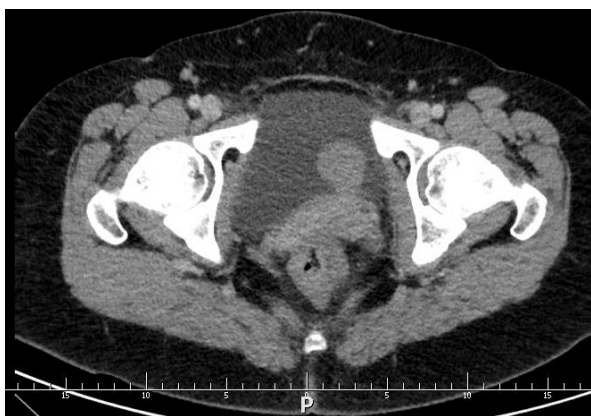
Leiomyoma of the left bladder wall - CT II-phase image- 31x31x28 mm bladder tumor
